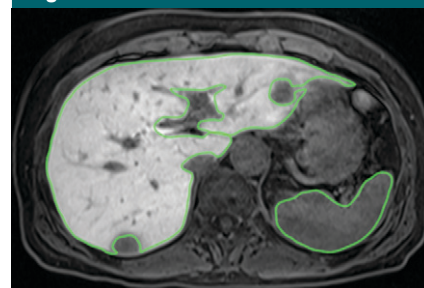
Patient 23. Axial 3D GRE T1-weighted MR image with fat suppression (3.5/1.42; flip angle, 15°) at 20 minutes after gadoxetate disodium administration obtained in a 64-year-old woman with a metastatic liver tumor. The contrast between the liver and spleen is high. Surrounding liver was proved to be normal at surgical resection. HUI is high (1.068 L), consistent with high ICG-PDR (0.207 sec⁻¹). Green lines = outlines of the liver and spleen.
